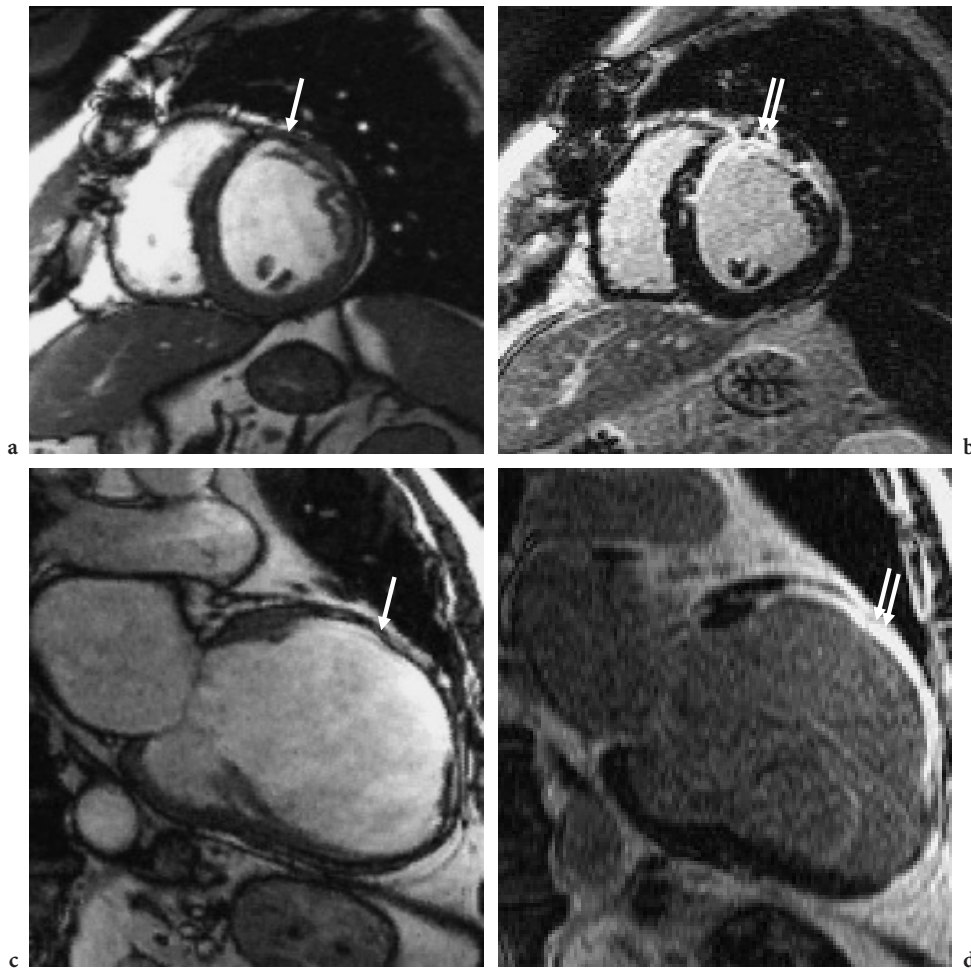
a, b TRUE-FISP cine and c, d delayed enhancement studies of a patient after myocardial infarction, as visualized in short-axis (a, c) and long-axis (b, d) views. The cine study clearly demonstrates thinning of the myocardium (*arrow*), while the delayed enhancement study reveals strong enhancement, which indicates infarcted tissue that will likely not benefit from revascularization (*double arrow*). (Images courtesy of the MRI division, Siemens, Erlangen, Germany)
